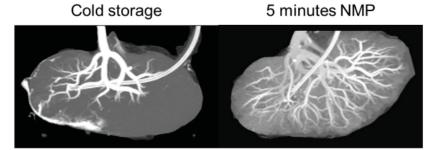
Kidney from a 69 yr old female donor after anoxic arrest with acute kidney injury on labs imaged after 43 hrs of cold ischemia. A) CT image after cold storage. B) 30 minutes later, after 5 minutes of NMP. 133% increase in normalized vascular volume from cold storage to NMP.
